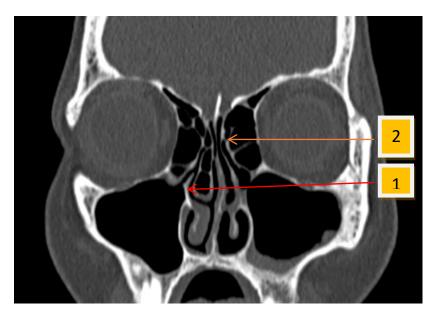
PNS CT scan, bone window, coronal slice shows 1. normal angulation of the right uncinate process and type II uncinate process on left side.
